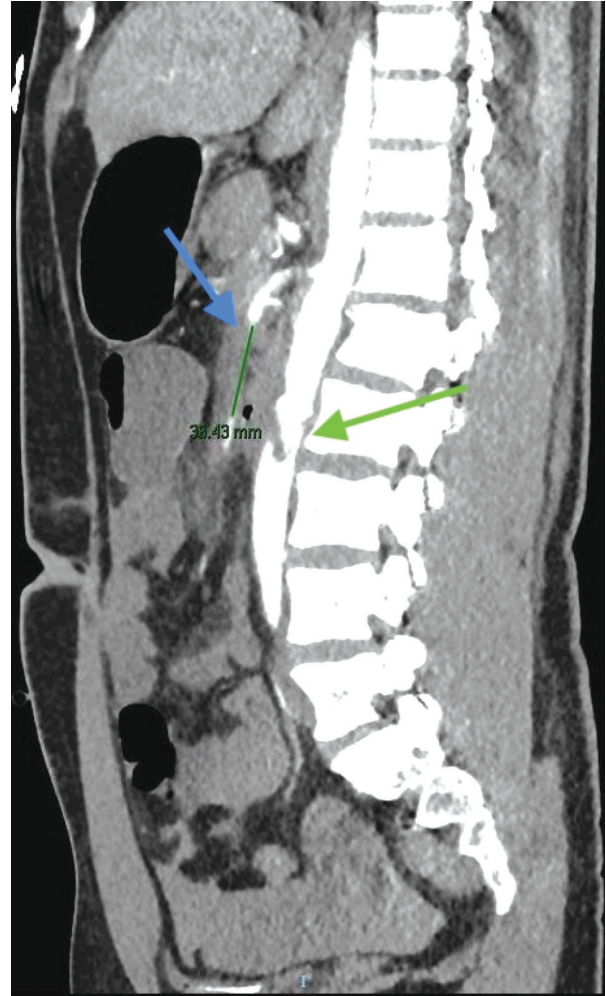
Sagittal CT angiography section of the lesion in the infrarenal aorta (green arrow) and 36.43 mm thrombosis of the superior mesenteric artery (blue arrow).
